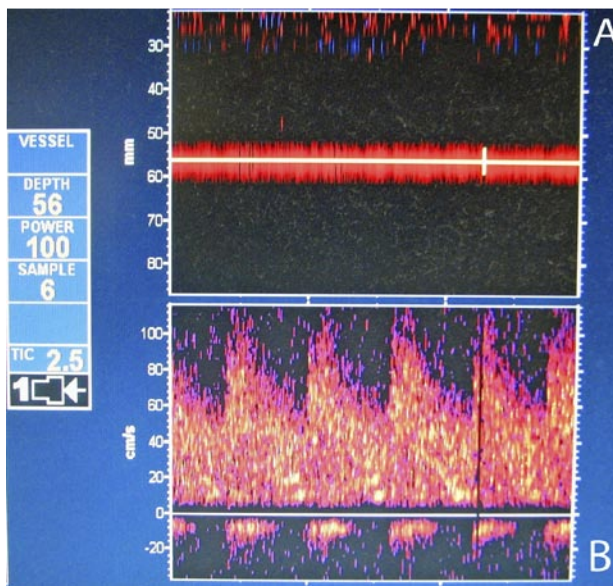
Middle cerebral transcranial Doppler ultrasonography, as seen on M-mode transcranial Doppler machine screen. A) The top of the screen shows the power M-mode Doppler signal. The sampling depth is 56 mm. B) Pulsed wave Doppler. Systolic, diastolic, and time-averaged mean values are calculated from the flow velocity waveform.
